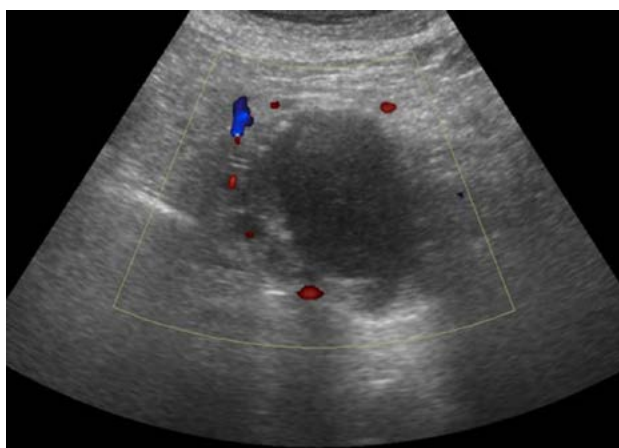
Follow-up color Doppler ultrasonography 6 days after the interventional treatment shows no more vascularity within the pseudocyst.
